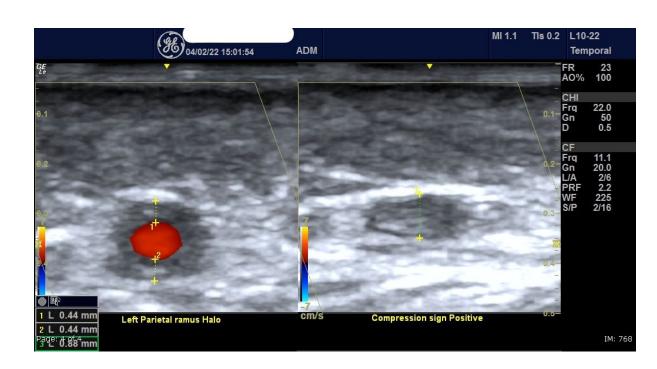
Halo sign (Left) and Compression Sign (Right) in the parietal ramus of the superficial temporal artery. Images acquired with GE Logiq e Ultrasonography machine using Linear 10-22 MHz probe.
